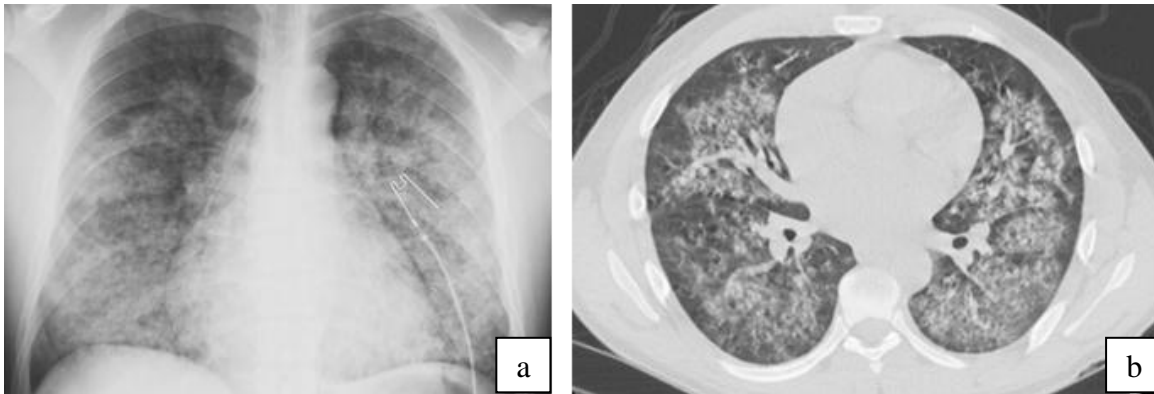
Initial chest x-ray (a) and non-contrast chest CT (b) images at presentation. There was extensive diffuse symmetric bilateral air space opacities primarily involving the lower lung zones characteristic of diffuse pulmonary hemorrhage.
